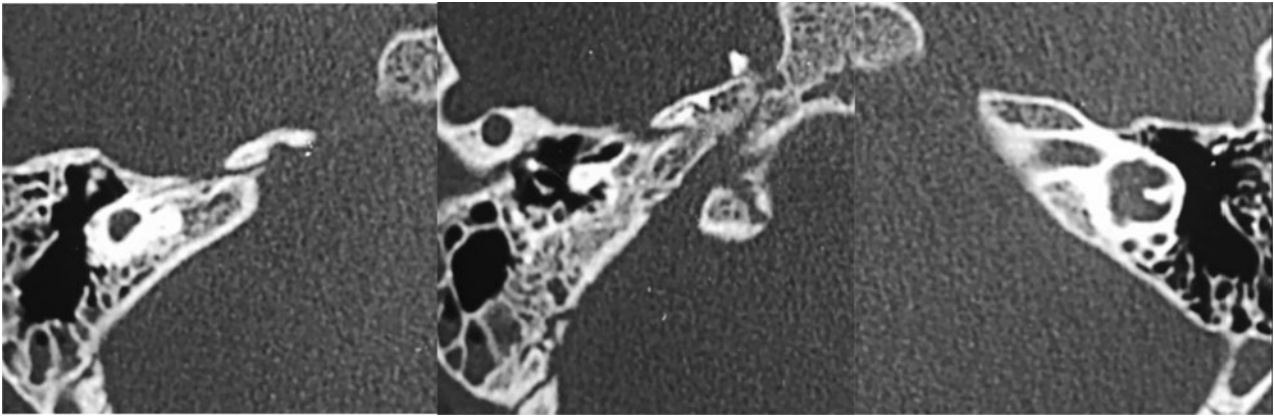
Computed tomography axial section of cochleovestibular malformation type IV.
